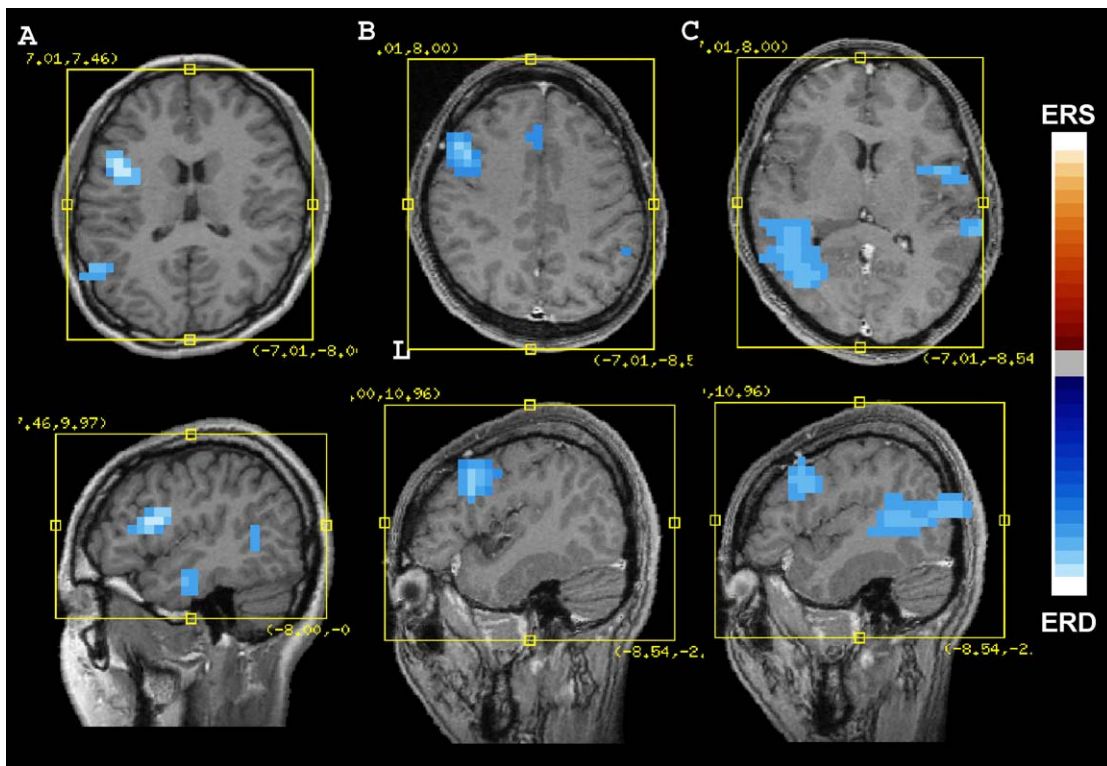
Representative SAM statistical images displayed on the individual MR images showing the desynchronization related to silent reading in the low gamma band (25–50 Hz) in the left inferior frontal gyrus (A), the left middle frontal gyrus (B), and the bilateral middle and superior temporal gyrus (C). Blue areas surrounded by a black line indicate significant ERD. SAM: synthetic aperture magnetometry. ERD: event-related desynchronization.
